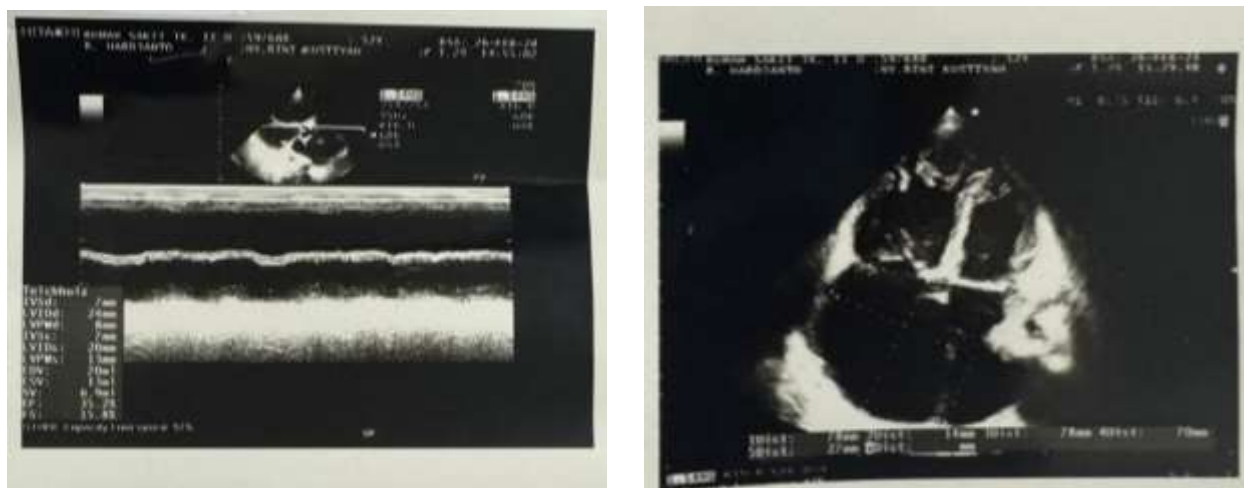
Transthoracic echocardiography showed Ejection Fraction of 35.2%, and dilatation of Left Atrium, Right Ventricle, and Right Atrium
